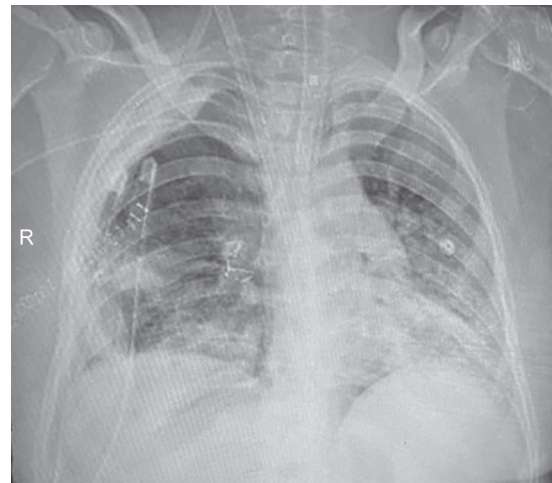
Chest x-ray 4th postoperative
